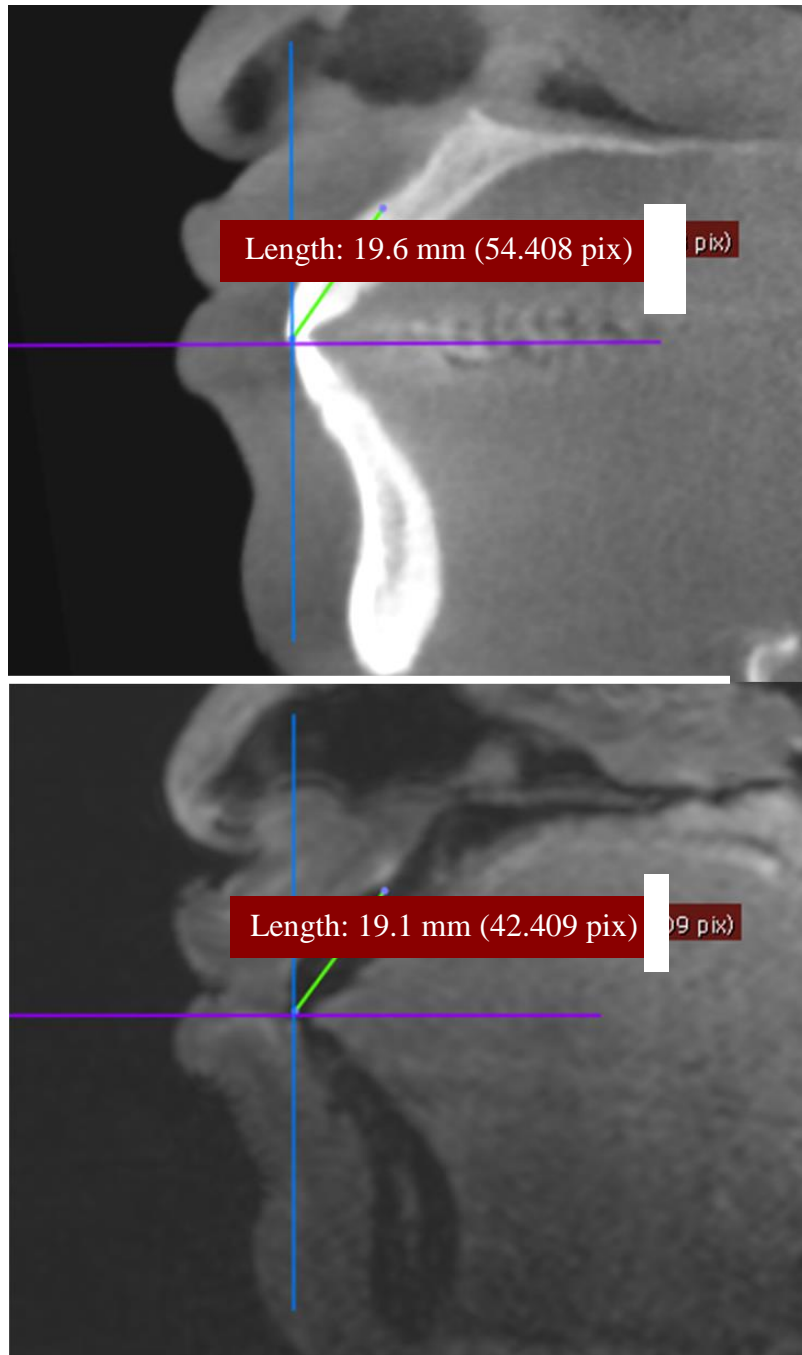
Tooth length measurement methods: (A) CBCT, (B) MRI. Green lines represent apparent tooth length, blue lines represent location of propagated point in the frontal plane, and purple lines represent location of propagated point in the axial plane.
